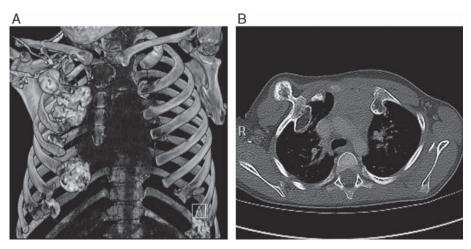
A, Three-dimensional computed tomographic (CT) scan showing multiple intrathoracic and extrathoracic osteochondromata. This patient had a known multiple hereditary exostoses diagnosis. The patient underwent multiple surgeries for symptomatic osteochondromata. During evaluation of painful osteochondromata of the chest wall we found these prominent intrathoracic and extrathoracic osteochondromata. B, Axial view CT scans showing intrathoracic and extrathoracic osteochondromata. As we expected based on this CT scan, intraoperatively we found several large osteochondromata along the anterior chest wall that abutted the heart and pericardium.
